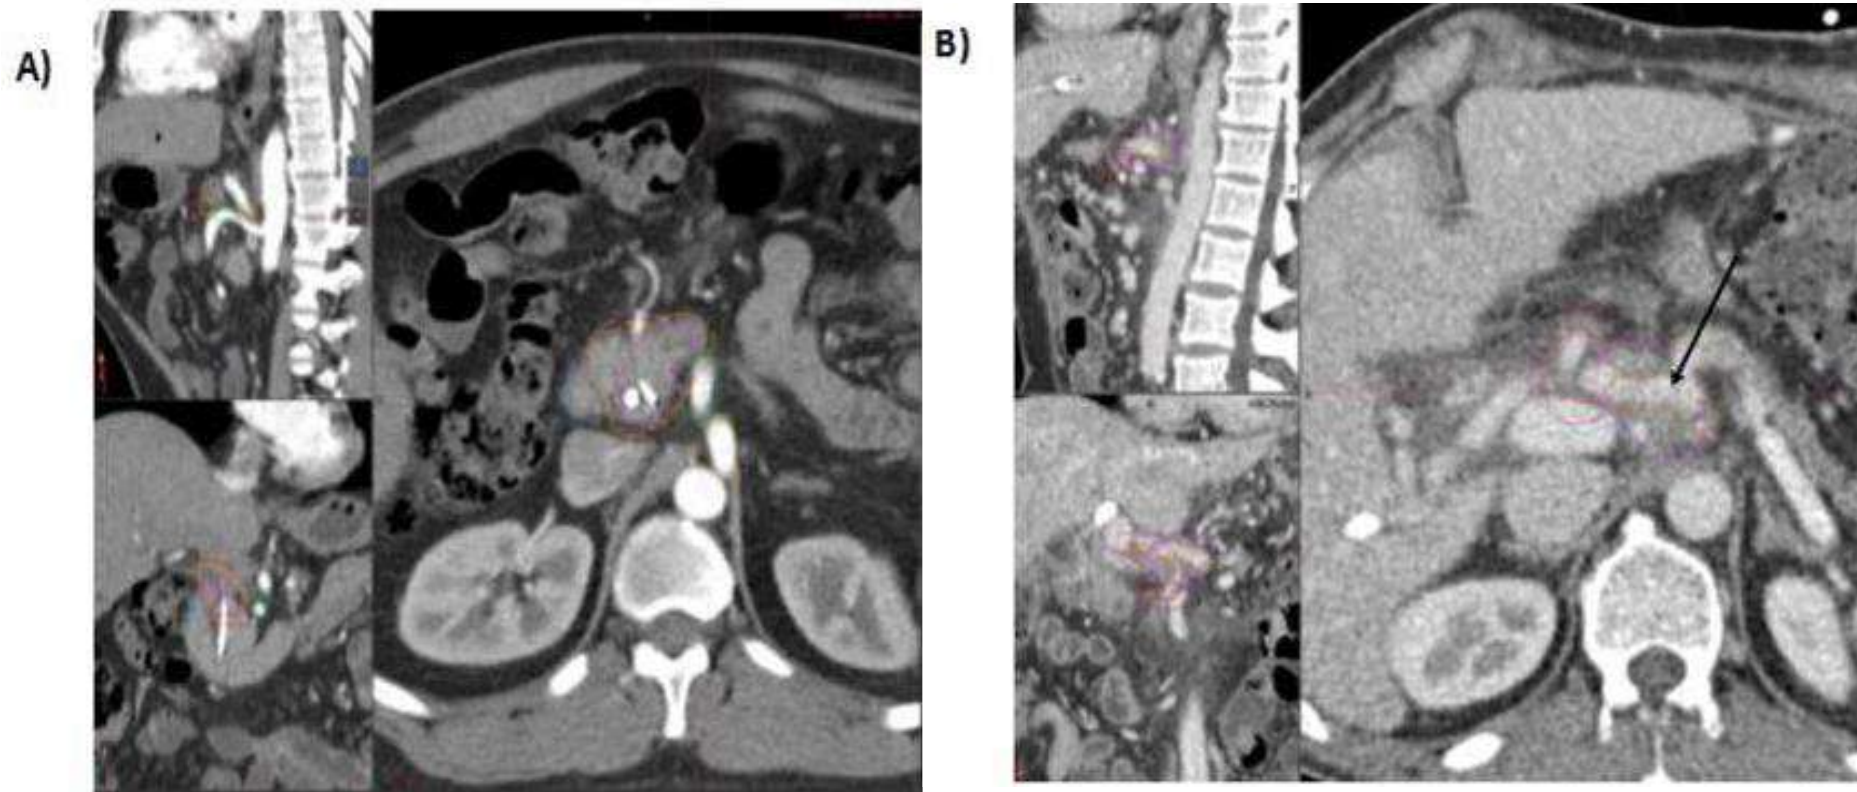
(A) Patient with borderline resectable tumor due to common hepatic artery abutment treated to the primary tumor alone. A local only recurrence occurred 12 months following surgery at the celiac artery as the first site of failure. (B) CT at time of recurrence fused to planning CT revealing the recurrence volume marginal to the original PTV (arrow)
